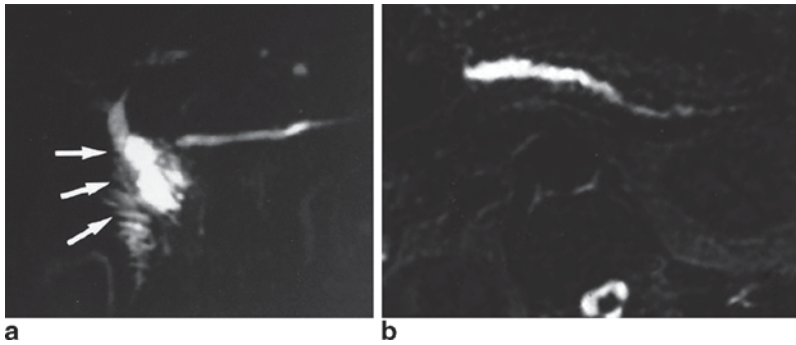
Secretin-stimulated MRI. a Normal result showing normal diameter duct with free flow into jejunum (arrows) indicating no obstruction at the pancreatico-jejunosotomy anastomotic (PJA). (With permission from
